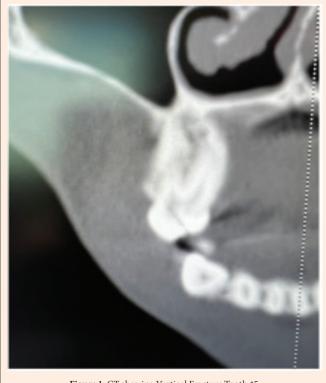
CT showing Vertical Fracture Tooth #5.
